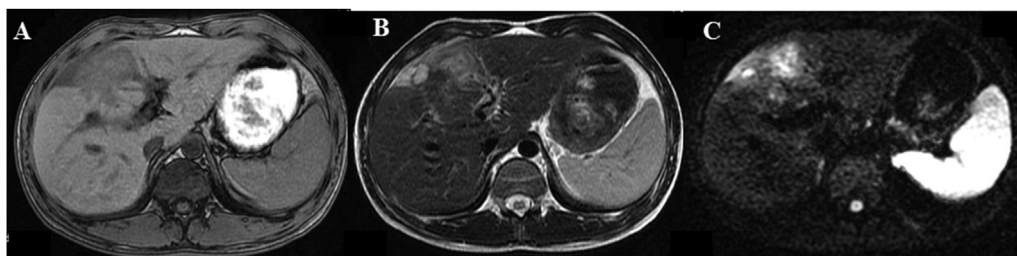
Magnetic resonance imaging (MRI) revealed an irregular mass measuring 9 cm that showed hypointensity in T1(A), and hyperdensity in T2(B)/DWI(C).
